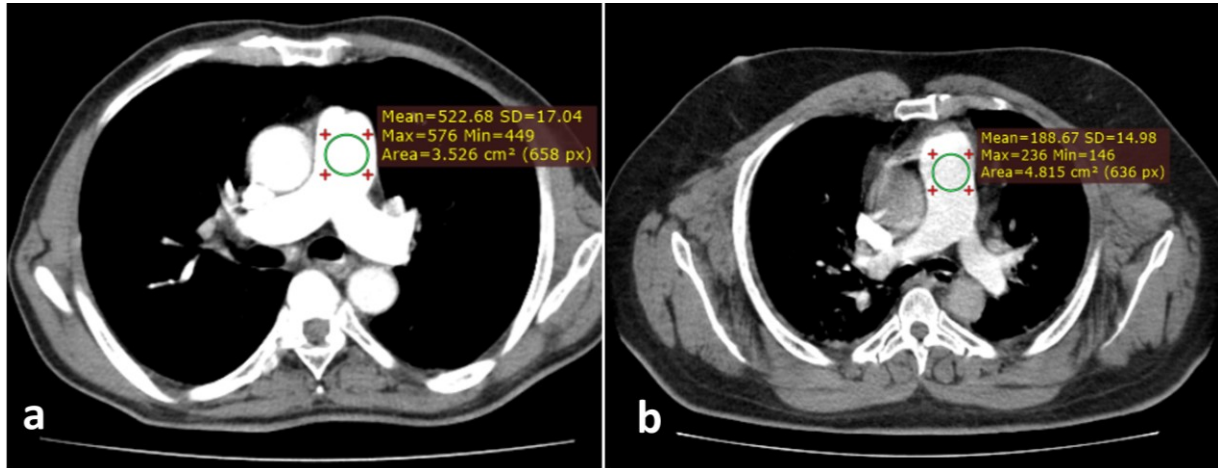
Axial pulmonary CT angiogram sections passing through the trunk of the pulmonary artery. Image a: optimal enhancement, average density of the trunk of the pulmonary artery measured at 522 HU. Image b: insufficient enhancement, average density of the trunk of the pulmonary artery is measured at 188 HU.
